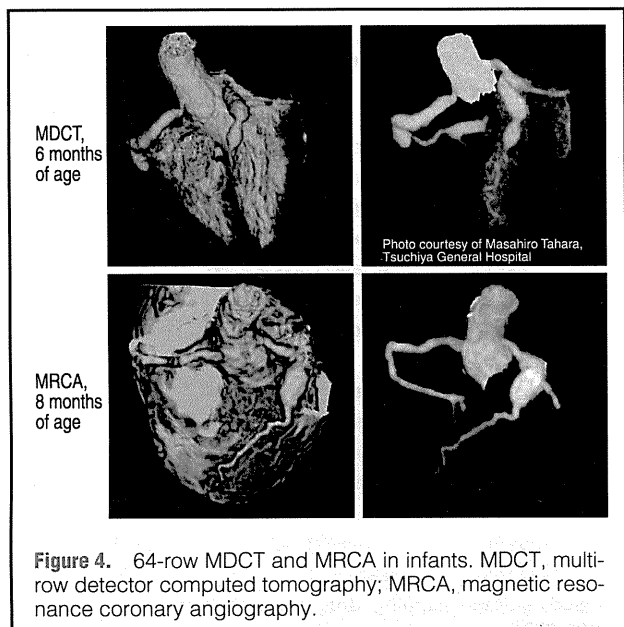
64-row MDCT and MRCA in infants. MDCT, multi-row detector computed tomography; MRCA, magnetic resonance coronary angiography.
